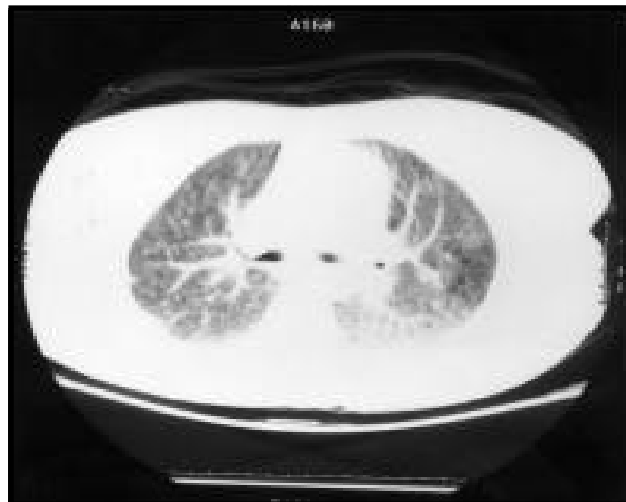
An axial CT scan of the chest demonstrating multiple pin like miliary lesion in both lungs.
